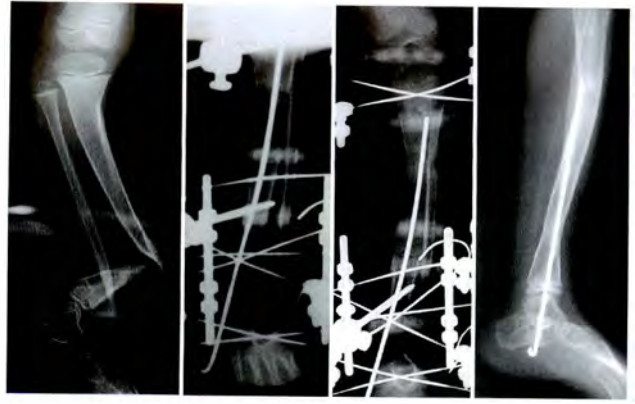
Serial Radiograph of Patient 4
